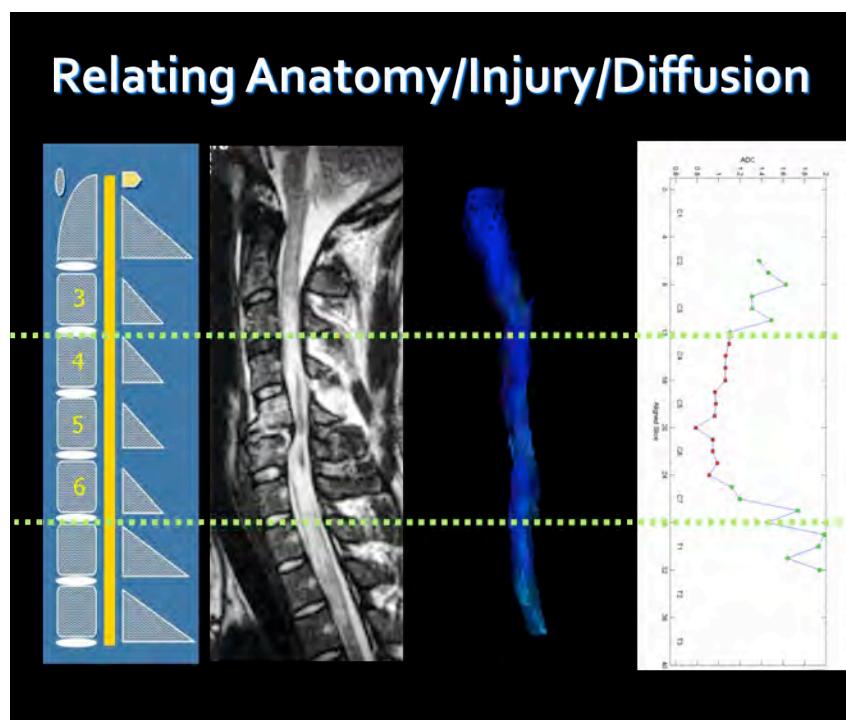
Mapping span of injury to anatomic location with conventional MRI and diffusion metrics.
